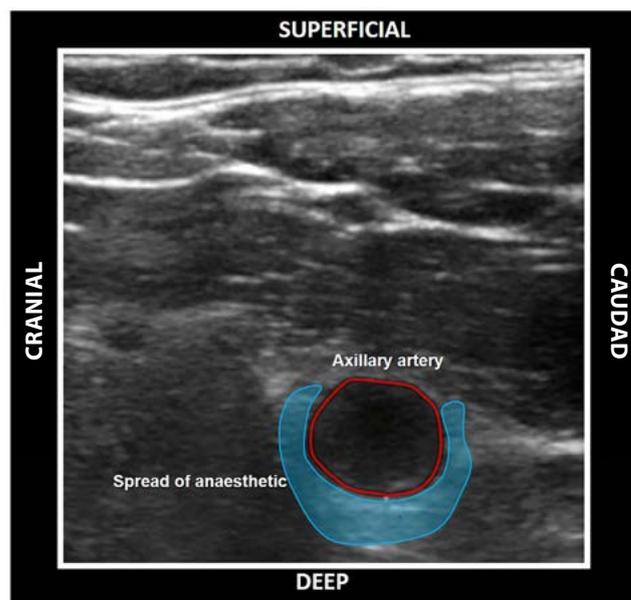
Spread of local anaesthetic solution (hypoechoic area high around the artery) around the BP, concealing it from view on the ultrasound machine.
